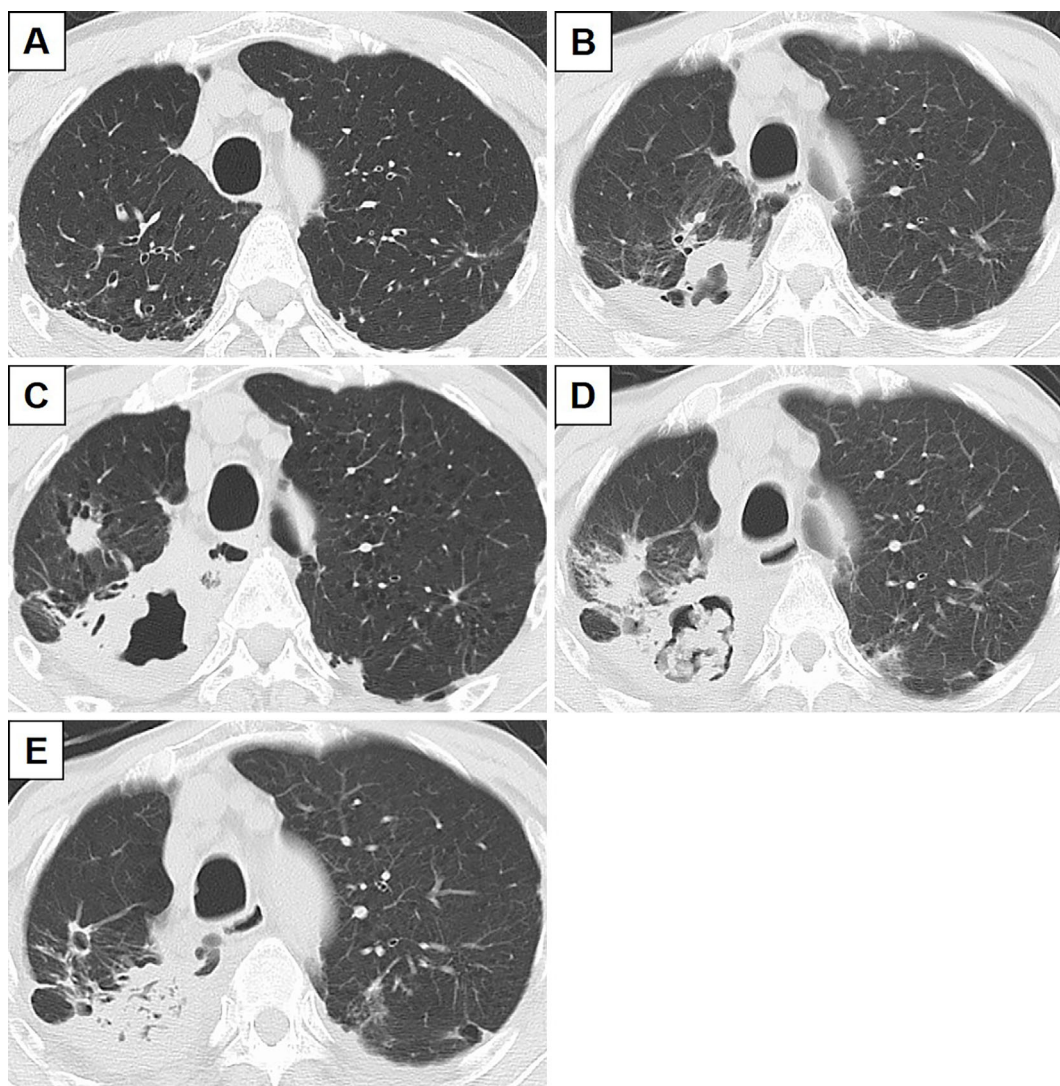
Chest computed tomography (CT). Chest CT 8 years before the patient's admission to our hospital showing a mild right subpleural consolidation lesion (A). Chest CT on July 2016 demonstrating a cavity and thickened peripheral lesion (B). After 9 months without antibiotic treatment, the cavity and thickened peripheral lesion were becoming larger and thicker (C). After 7 months of antimycobacterial treatment, the cavity and thick peripheral lesion had not improved, and a fungus ball appeared in the cavity (D). After 7 months of combination treatment, the fungus ball had almost disappeared.
